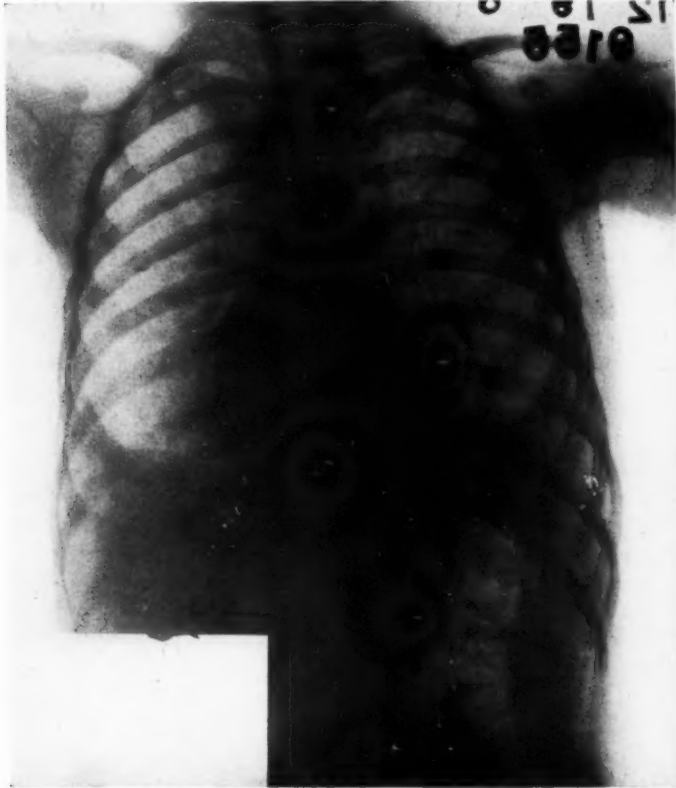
Chest roentgenogram of the case observed personally (Case I—Case 41 of table) taken the day after admission, December 19, 1928, showing beginning effusion at the right and possibly the left base and early bronchopneumonia. This report and the three that follow are by the late Dr. Webster W. Belden, of The New York Hospital.
